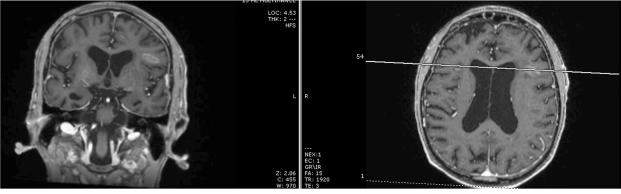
Brain magnetic resonance imaging 48 hours after initial presentation.
